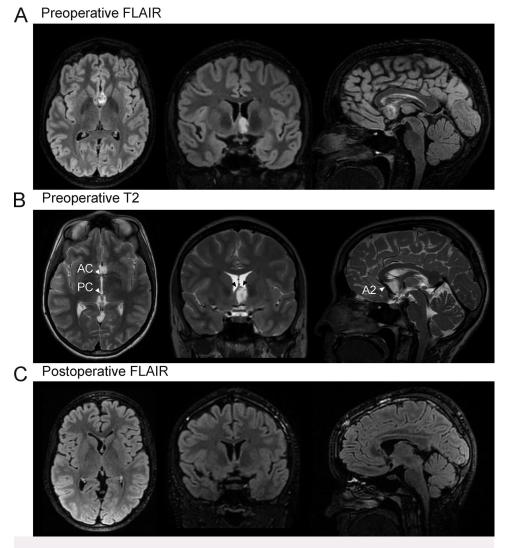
A: Preoperative axial, coronal, and sagittal FLAIR MRI sequences demonstrating a 1.3×1.7 -cm T2 hyperintense lesion centered in the left septal area. B: Preoperative axial, coronal, and sagittal T2-weighted MRI sequences again demonstrating the lesion, as well as anterior commissure (AC), posterior commissure (PC), fornices (*black arrowheads*), and A2 branch of the anterior cerebral artery (*white arrowheads*). C: Postoperative axial, coronal, and sagittal FLAIR MRI sequences demonstrating gross-total resection of the tumor.
